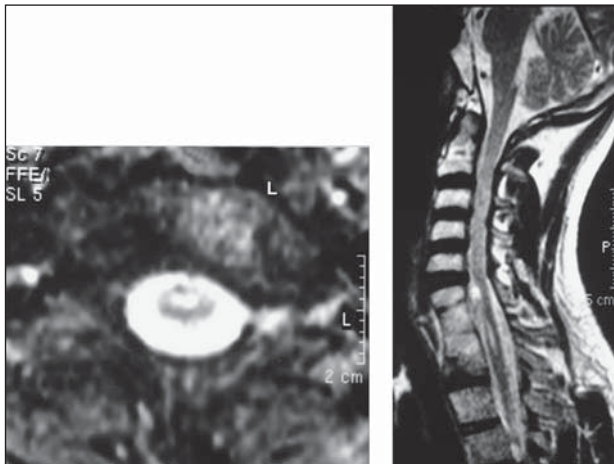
(A, B). T1 and T2-weighted sagittal and transverse images show cervical (C) 6-thoracic (T) 2 vertebral fusion and C7-T1 syringomyelia.
